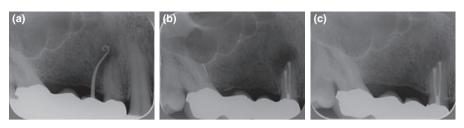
(a) A 48-year-old male with a fistulous tract in the region of the maxillary first right premolar. A radiograph showing a gutta-percha cone inserted in a buccal sinus tract to the periapical radiolucency of tooth 14. (b) The situation immediately postoperatively. (c) Two years postoperatively. The radiograph shows complete periapical healing.
